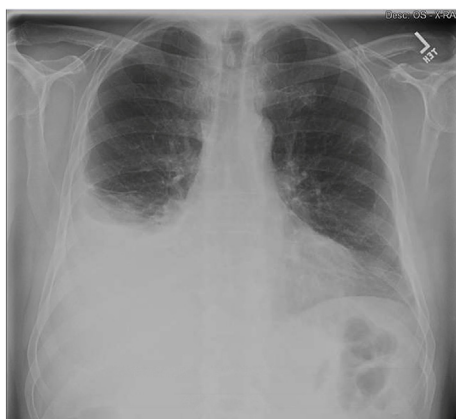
Plain radiograph with recurrent moderate pleural effusion.
